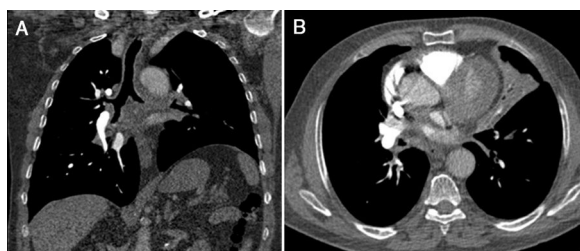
(A) Post-contrast coronal CT scan reveals diffuse thickened tracheobronchial wall. (B) Axial CT scan shows atelectasi in the lingular segment of the left upper lobe.
